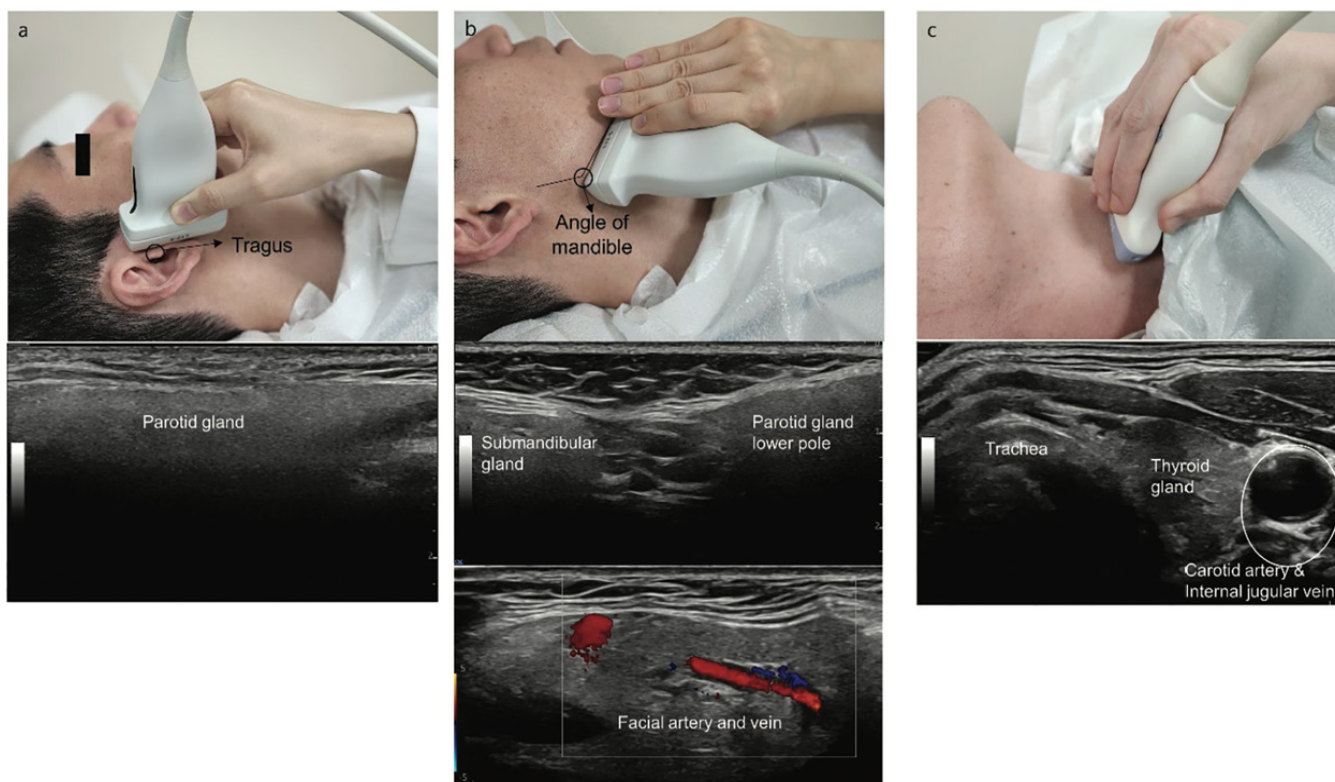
Ultrasound probe positioning and technique to access the parotid, submandibular, and thyroid glands.
